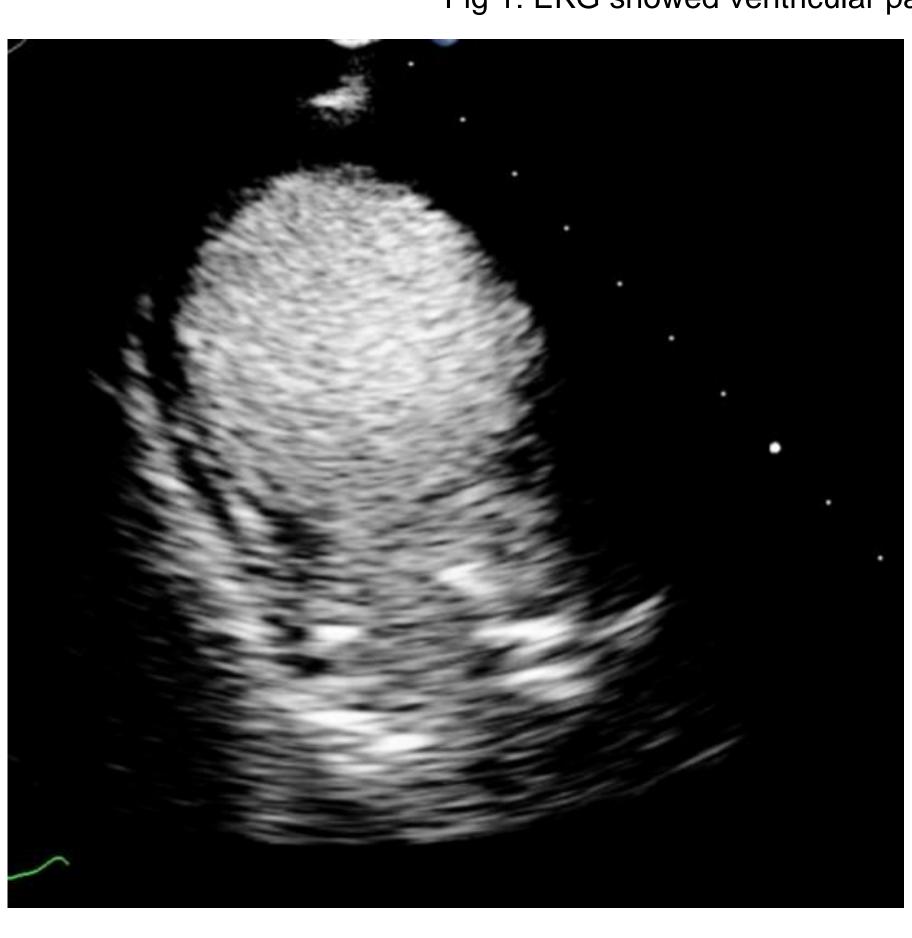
Echocardiogram showed dilated moderate aortic regurgitation, dilated left atrium, akinesias of the apical and mid-ventricle segments, basal segments hypercontractility, and apex dilation, LVEF of 25-30%
